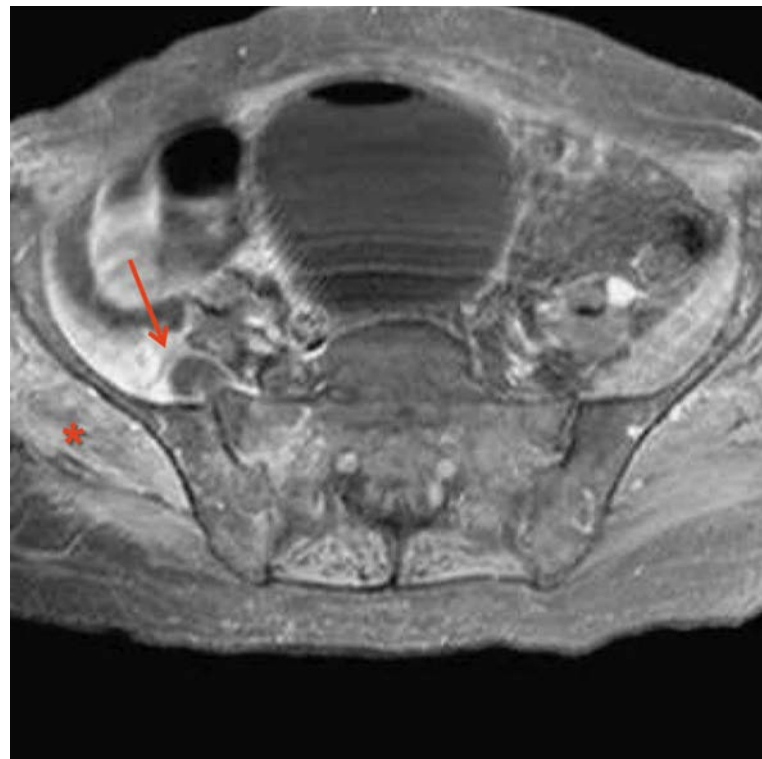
Nuclear magnetic resonance image showing sacroiliitis, inflammation of the gluteus maximus and medius muscles, iliacus muscle and a fluid collection in the anterior region of the right sacroiliac joint. Red arrow indicates the fluid collection in the anterior region of the sacroiliac joint; red asterisk indicates inflammation of the muscles.
